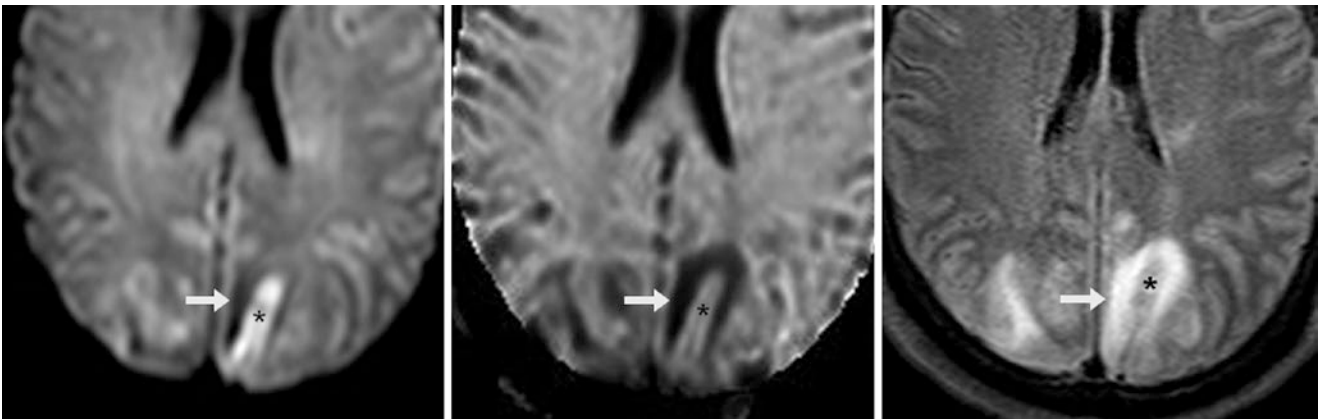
A 55-year-old with PRES from gemcitabine. On DWI at 1.5 T (*left*), there is T2 washout from vasogenic edema (*arrows*) within the left occipital region, with gyriform bright signal centrally (*asterisk*) within the larger area of edema. An exponential DWI (*middle*) removes
